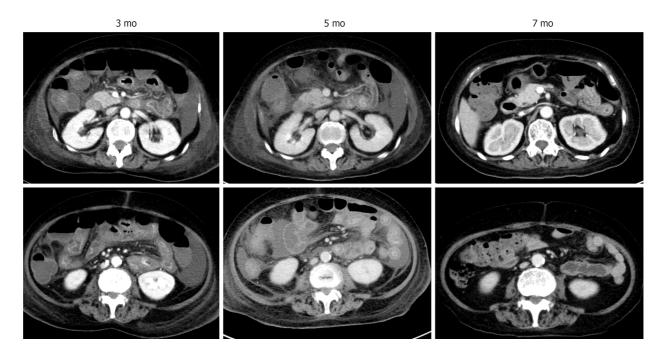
Improvement of computed tomography findings. The computed tomography images were taken at different time points after the second hospitalization, as indicated.
